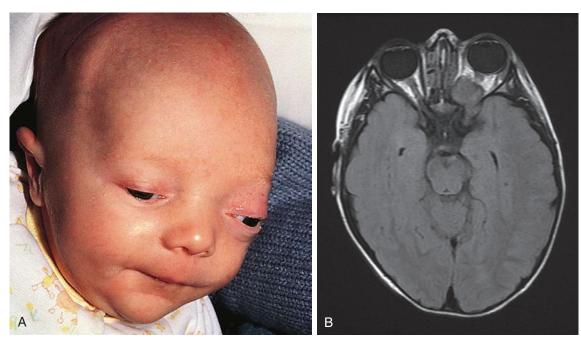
A, Retro-orbital rhabdomyosarcoma. This child demonstrates proptosis due to the retro-orbital tumor, as well as a large head due to the presence of increased intracranial pressure. B, Rhabdomyosarcoma of the orbit with proptosis shown on axial T₂ FLAIR (fluid-attenuated inversion recovery) magnetic resonance image.
